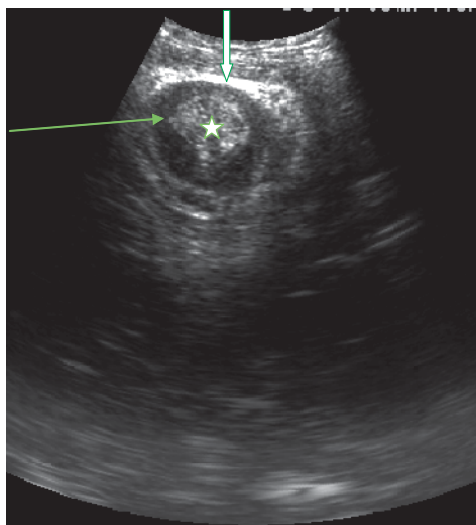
Axial transperineal ultrasound of the mid-anal canal showing images which resemble those obtained with endoanal sonography (Arrow internal anal sphincter, block arrow external anal sphincter). The anal mucosa is shown as a hyper-echoic central region (star).
